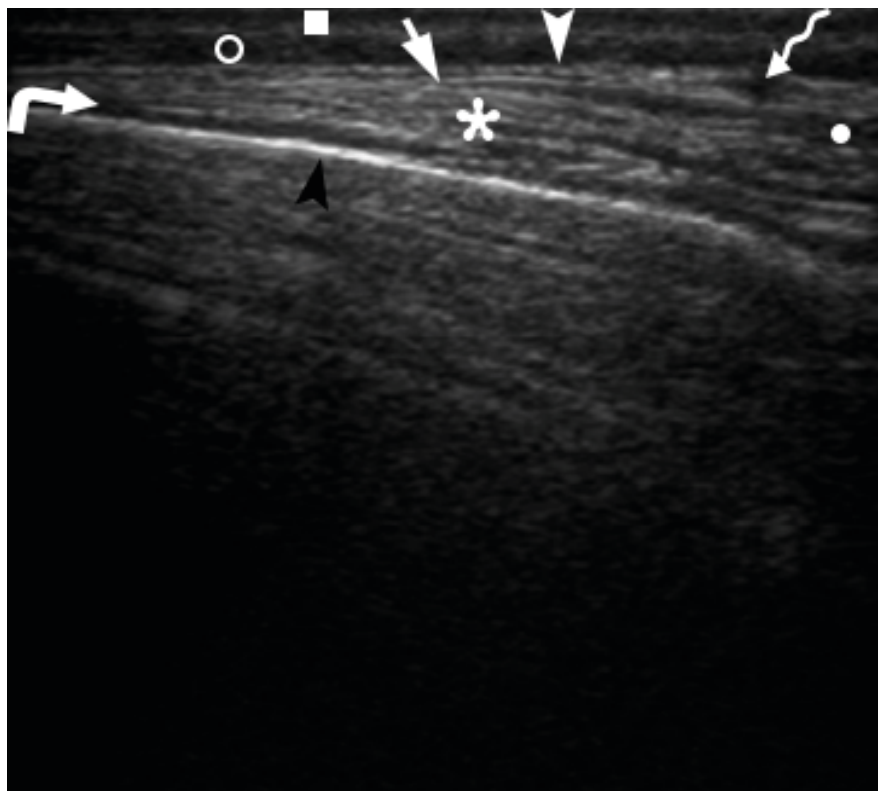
Oblique gray scale sonogram of the left asymptomatic temporal region shows no signs of inflammation in subcutaneous adipose tissue (*open circle*) or in other layers. Epidermis and derma are indicated by *quadrate*, tempoparietal fascia is indicated by *white arrowhead*, lumen of the vessel – by *waved arrow*, place of split of temporal fascia – by *arrow*, fat pad of temporal fascia – by *small closed circle*, tendons of temporal muscle – by *asterisk*, cellular tissue beneath temporalis – by *curved arrow*, outer surface of the bone of the lateral side of the skull – by *black arrowhead*. Printed with permission and copyrights retained by O.S.C. and I.I.F.
